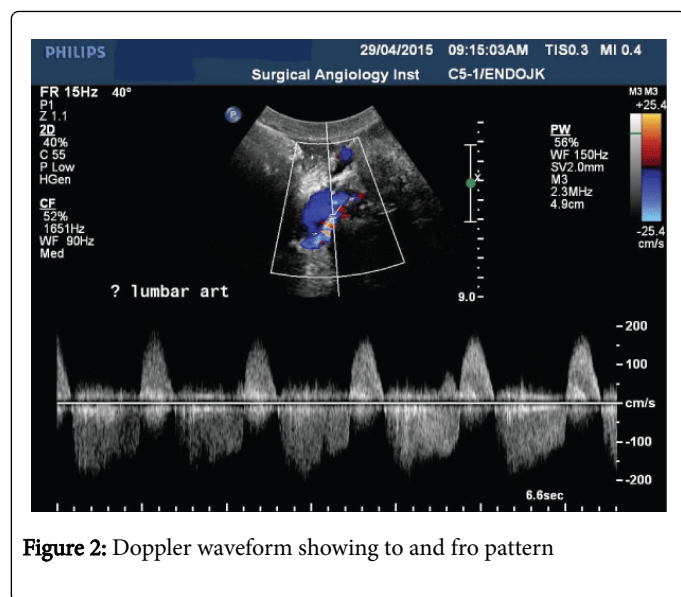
Doppler waveform showing to and fro pattern
